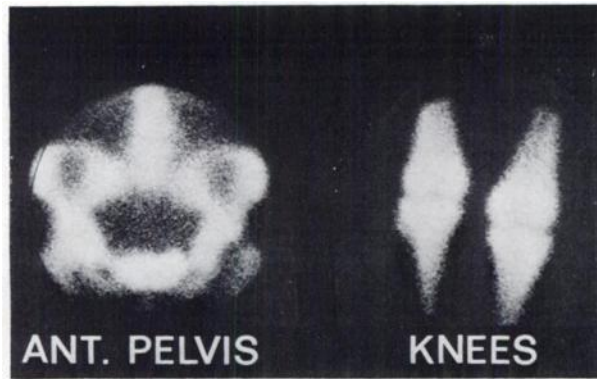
Bone scintigram obtained from Patient 2. Decreased uptake is seen in left femoral head (left). Increased uptake is noted in distal femur on anterior view of knees (right).
